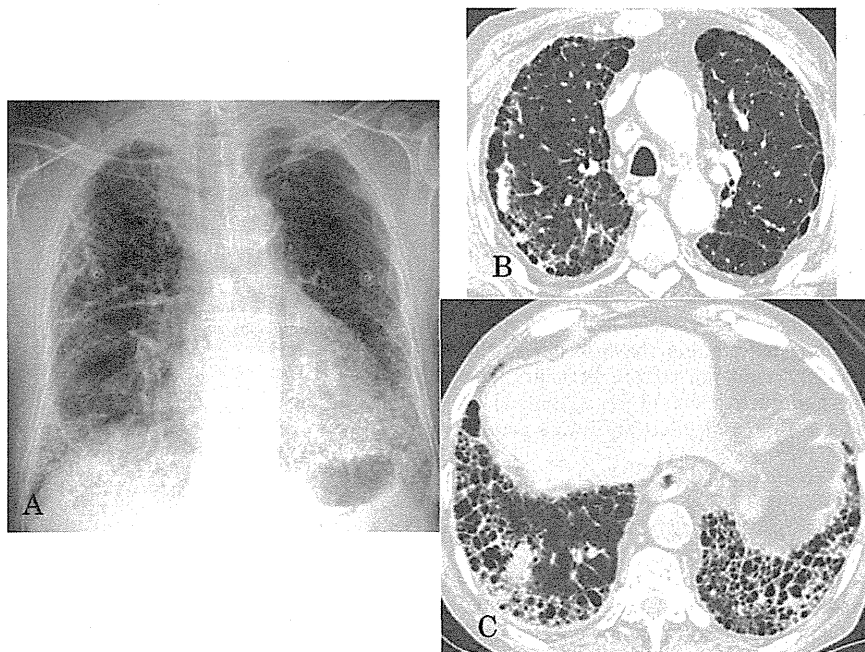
Chest radiography and chest computed tomography on the 13th hospital day demonstrates the infiltrative opacities in the right upper and both lower lobes.
